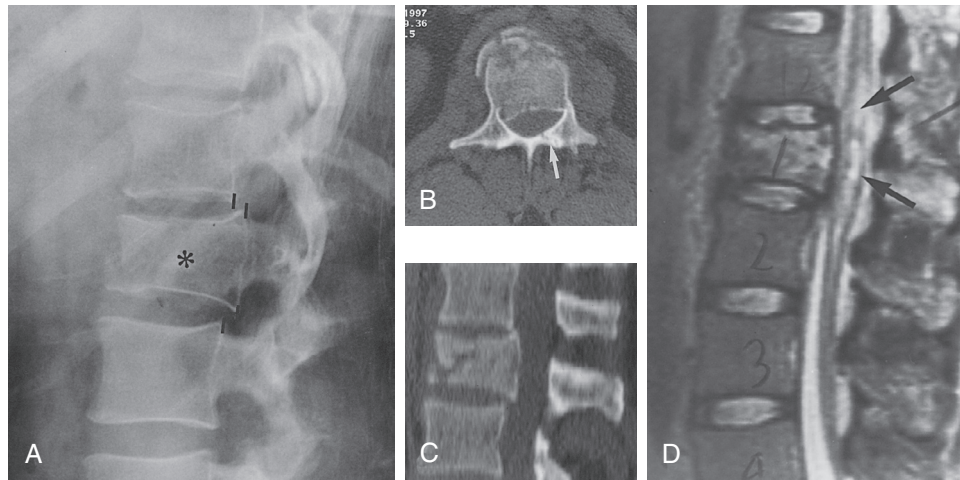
■ Posttraumatic vertebral body compression fracture. Lateral plain film (A) of thoracolumbar junction reveals a compression fracture involving L1 vertebral body (*asterisk*). Decreased height of vertebral body and inferior anterior corner fracture are well seen. Retropulsed body can also be seen when outline of adjacent vertebral bodies (*lines*) are compared. Axial (B) and sagittal reconstructed (C) computed tomography scans of same patient add substantial detail to degree of canal narrowing secondary to retropulsed fragment. Left lamina fracture (*arrow*, B) is also seen—not apparent on the plain film. D, Sagittal T2-weighted magnetic resonance imaging demonstrates compression fracture of L1 and retropulsed posterior body, as well as contusion and swelling of conus (*arrows*) as a direct result of compression fracture.
